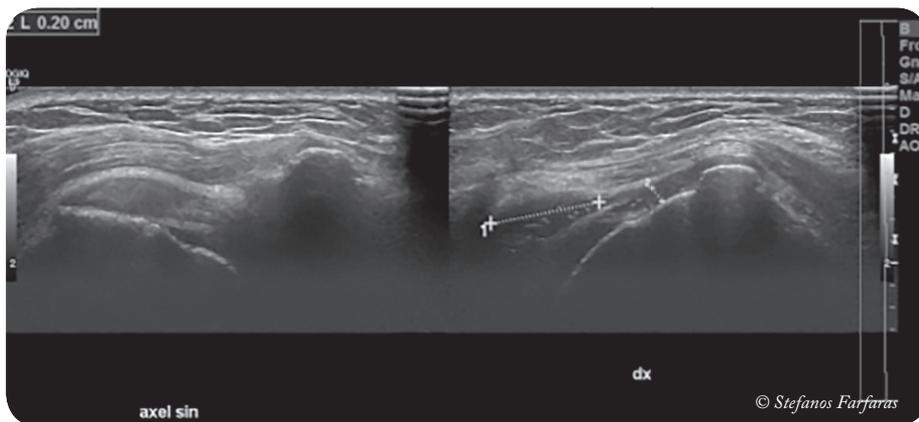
Bilateral ultrasound image of a patient. To the right a full thickness supraspinatus tear is visualized (left shoulder, index side). To the left (contralateral side) an intact supraspinatus tendon is visualized.*
